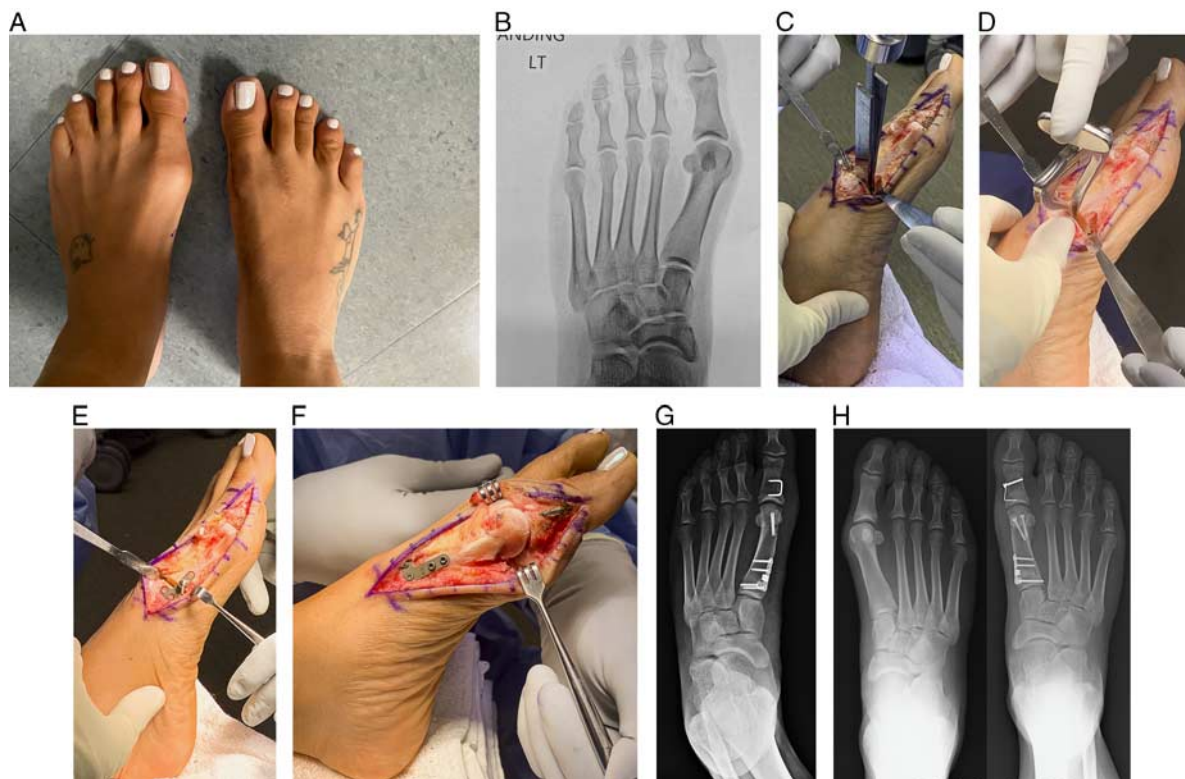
A, Clinical picture showing the 1-year postoperative result on the right foot and preoperative left foot. B, Preoperative left foot anteroposterior radiograph. Note an increase in distal metatarsal articular angle. C, After completing the oblique osteotomy at the base of the first metatarsal, the series of osteotomes are placed as shown and tapped into place, establishing an opening wedge. D, Use of the small spreader aids in opening the wedge. E, Provisional fixation of the plate to check correction with fluoroscopic imaging. F, Final construct with proximal opening wedge osteotomy with cancellous graft placed. Note the distal biplanar chevron osteotomy and an Akin proximal phalanx osteotomy. G, Final anteroposterior radiograph of the left foot. H, This patient had previously undergone the same procedure on the right foot 1 year prior. Preoperative anteroposterior and postoperative anteroposterior right foot depicted at 1 year postoperatively.
